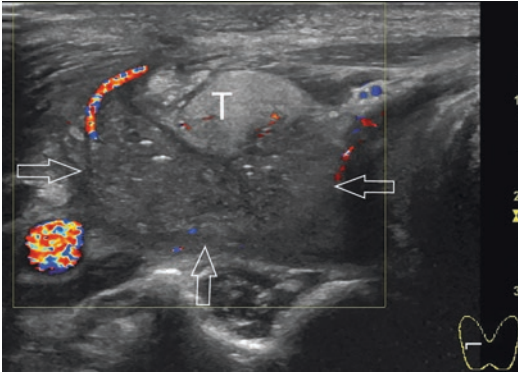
US imaging of neck tuberculous abscess. Transverse color Doppler US image taken at the level of the thyroid gland in a patient who presented with neck pain and right neck mass shows echogenic fluid collection (open arrows) posterior to the thyroid right lobe (T) causing anterior displacement of the thyroid gland. The fluid collection has peripheral vascular flow at the rim and absent vascular flow in the center
